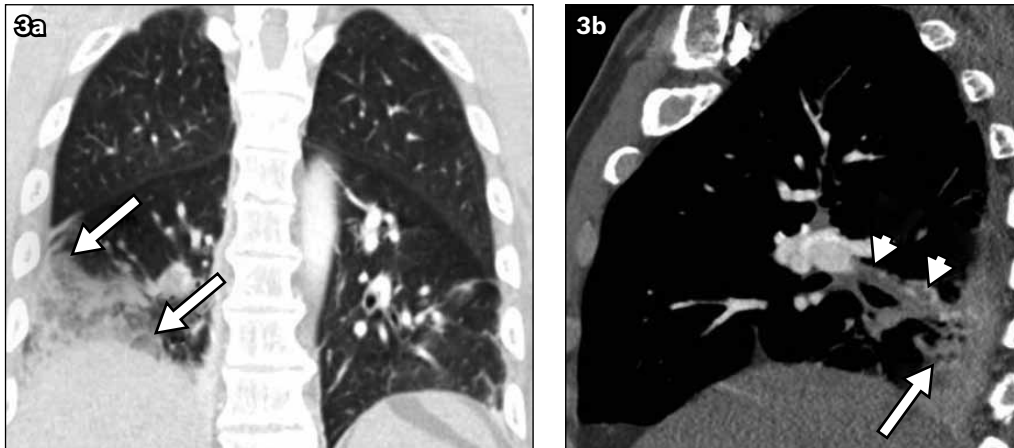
(a) Coronal CTPA image in lung window shows the peripherally located infarcted lung (arrows), corresponding to the Hampton's hump sign seen on the chest radiograph. (b) Sagittal CTPA image in mediastinal window shows thrombi within the right lower lobe segmental branches (arrowheads) and the peripherally located infarcted lung (arrow).
